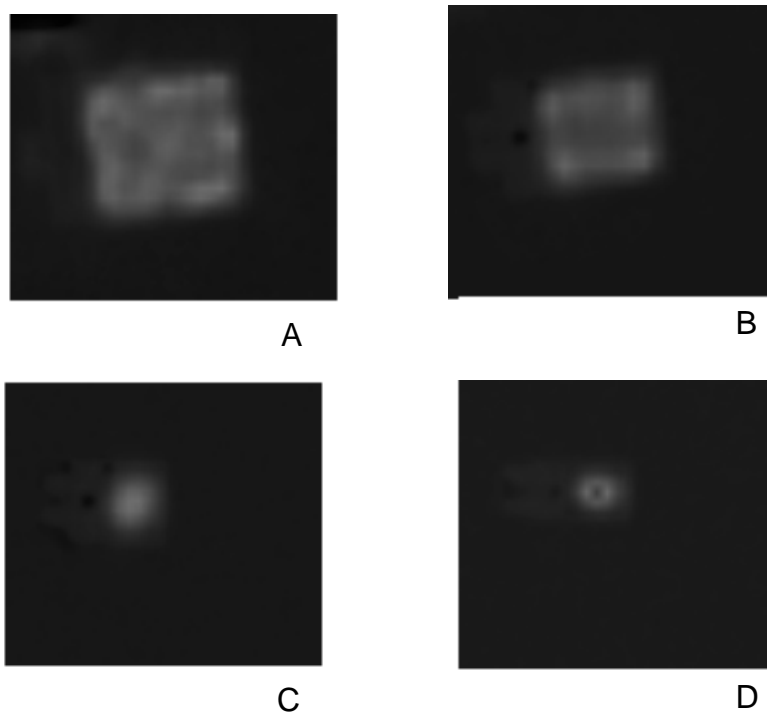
Reconstructed SPECT images obtained with Flash 3D and DEW-CT correction method, (A) Tumour I, (B) Tumour II, (C) Tumour III and (D) tumour IV.
